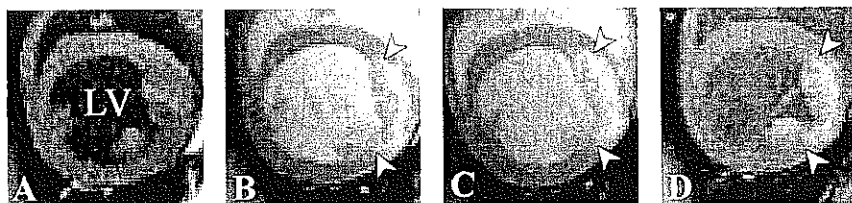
Contrast agent accumulation at different time points after administration is shown using contrast-enhanced cardiac MRI. The white arrow heads indicate the region of myocardial infarction and LV denotes the left ventricle of the heart. A Control short axis cardiac image (before Gd(ABE-DTTA) administration). No contrast can be observed between infarcted and non-infarcted areas. B 24 h after contrast agent administration. Accumulation of Gd(ABE-DTTA) in infarcted tissue (bright anteroseptal myocardial region) is apparent. C 48 h after contrast agent administration. D 7 days after Gd(ABE-DTTA) administration. Apparent signal enhancement (bright area in the myocardium) was observed in the non-viable cardiac tissue delineating a 1-week-old myocardial infarction while the healthy myocardium shows no signal enhancement (dark myocardial regions).
